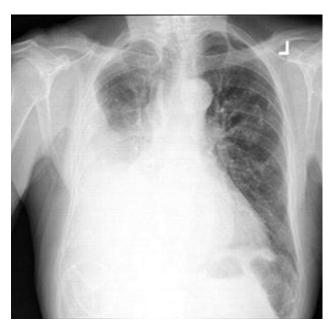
Chest roentgenogram of a patient with congestive heart failure and a pleural effusion.
